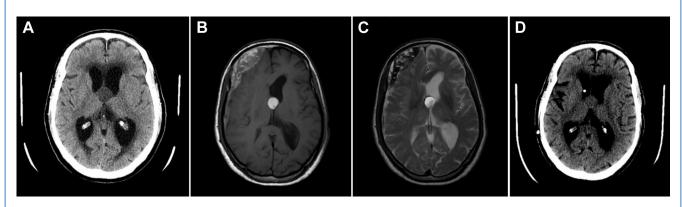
(A) Nonenhanced computed tomography scan showing a well-defined hypodense lesion in the third ventricle causing obstructive hydrocephalus. (B) T1-weighted magnetic resonance imaging showing a hyperintense signal of the colloid cyst. A large right frontal postoperative
